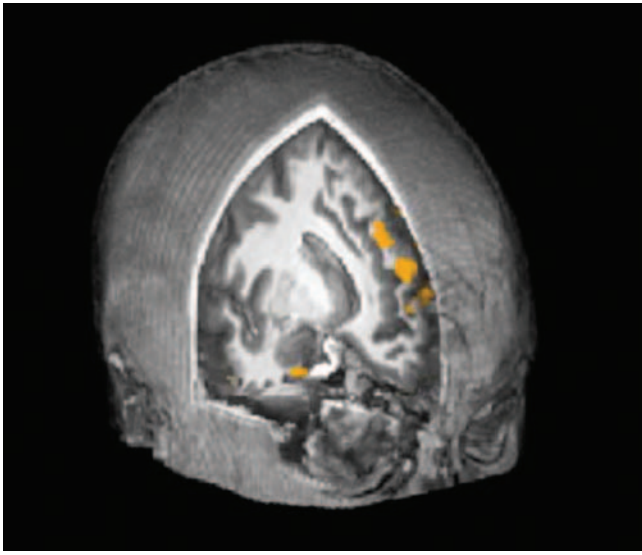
Left:* An activation map rendered on a three-dimensional magnetic resonance image showing regions in the medial prefrontal cortex. *Right:* How to find the prefrontal cortex. The entire frontal cortex is in front of the central sulcus, the vertical fold that runs from the top of the cortex down to the temporal lobe. Locate the central sulcus in this figure. The two purple gyri (hills) immediately in front of the central sulcus are called the motor and premotor cortex. The reddish-purple patch in front of that is called the supplementary motor cortex. However, the three shades of yellow in the frontal third of the whole cortex is prefrontal cortex, often considered the most ‘cognitive’ part of the brain. *Source:* Harenski and Hamann, 2006.
